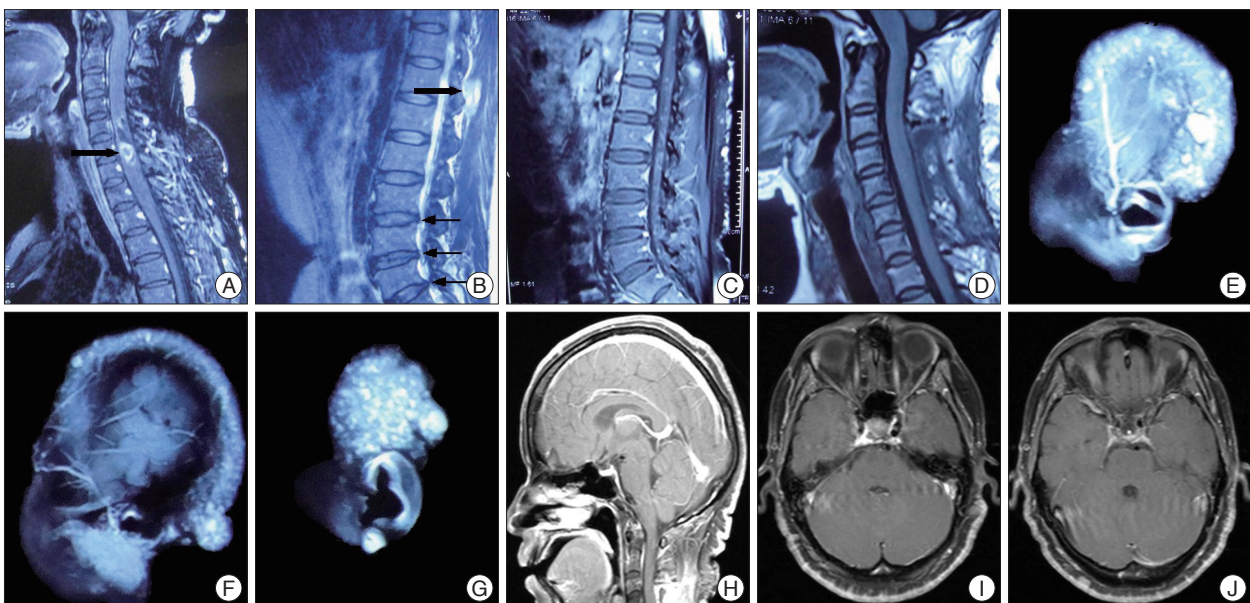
A : Spinal MRI shows a relative-demarcated, heterogeneously enhanced mass lesion accompanied by perifocal edema in C5-7 level (arrow). B : A left-sided T11 spinous process heterogeneously enhanced mass in soft tissue (thick arrow), and intervertebral disk hernia in L2-5 level (thin arrows). C, E, F, and G : Post-gadolinium T1 weighted sagittal imaging revealed widespread punctum enhancing lesion in her scalp and in T11-L5 level. D : Follow-up MRI revealed stable postsurgical changes in the C4-7 level with no evidence of tumor recurrence one year later. H, I, and J : Head MRI suggests no evidences of optic pathway glioma and neurofibromatosis 2.
